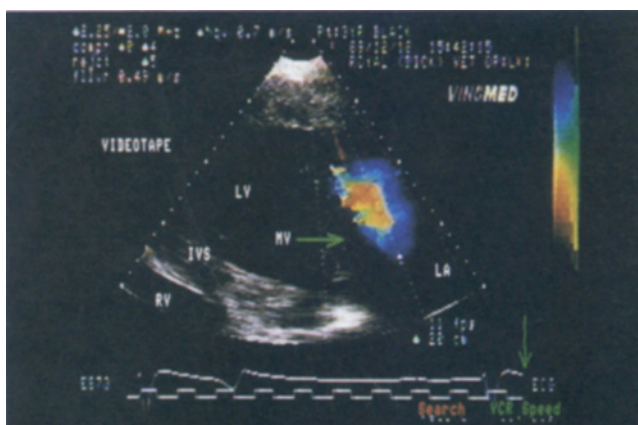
Colour flow study from a left parasternal long-axis apical view. A large blue signal with a central aliased core is shown on the left atrial side of the mitral valve. This colour signal was present for one colour frame only and was then replaced by the small regurgitant jet shown in Figure 10.
